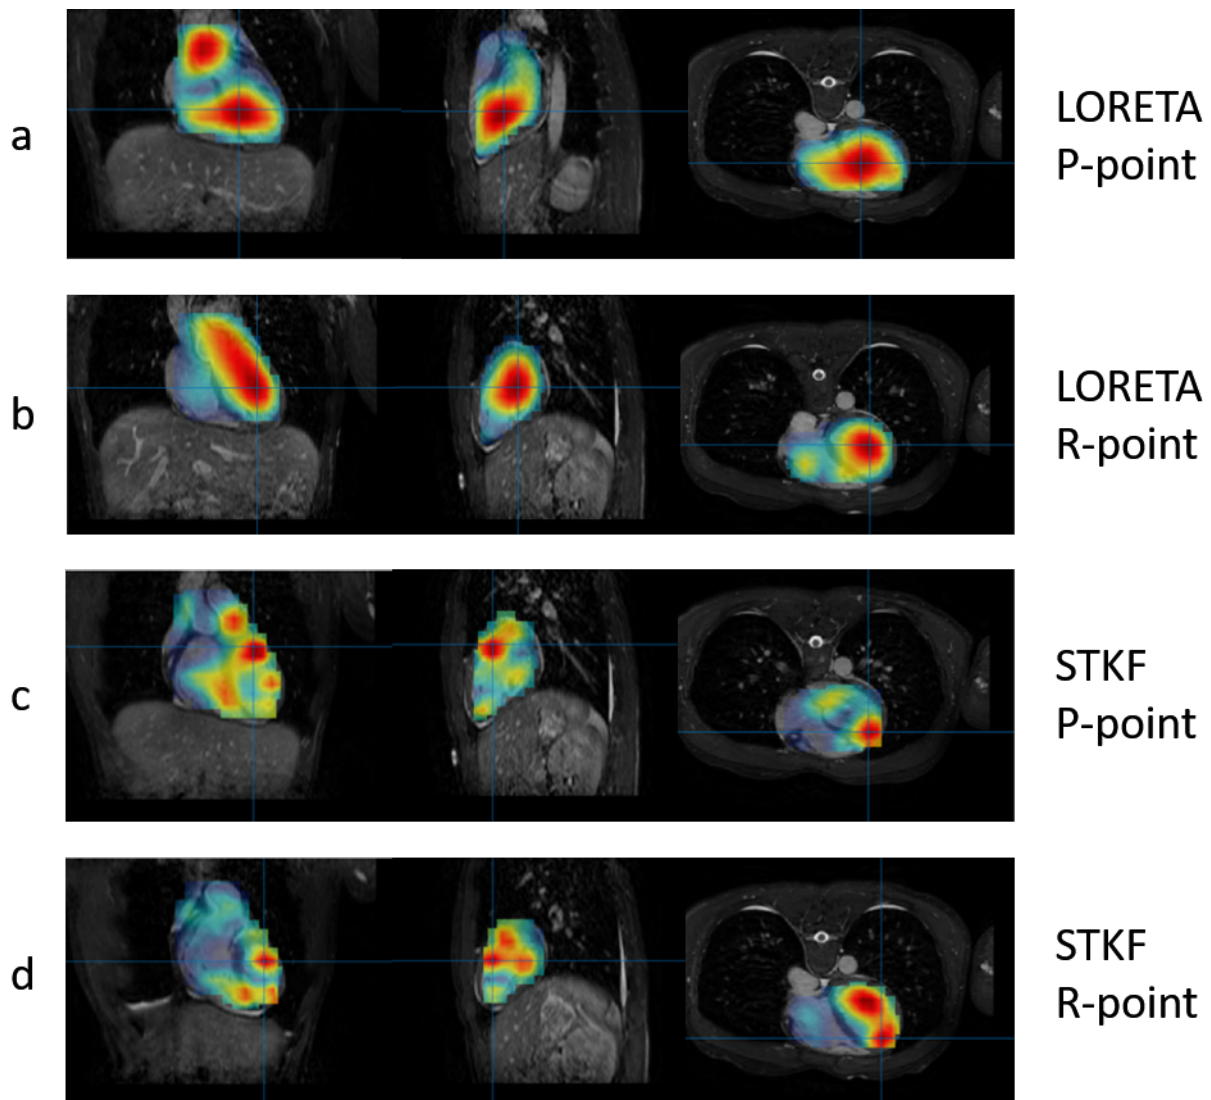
The source imaging results from the first dataset using LORETA and STKF at two times points of interest on the heartbeat cycle, namely the P-point and the R-point. The source activity results are superimposed on the MRI to show the heart activity in accordance with the heart anatomy.
